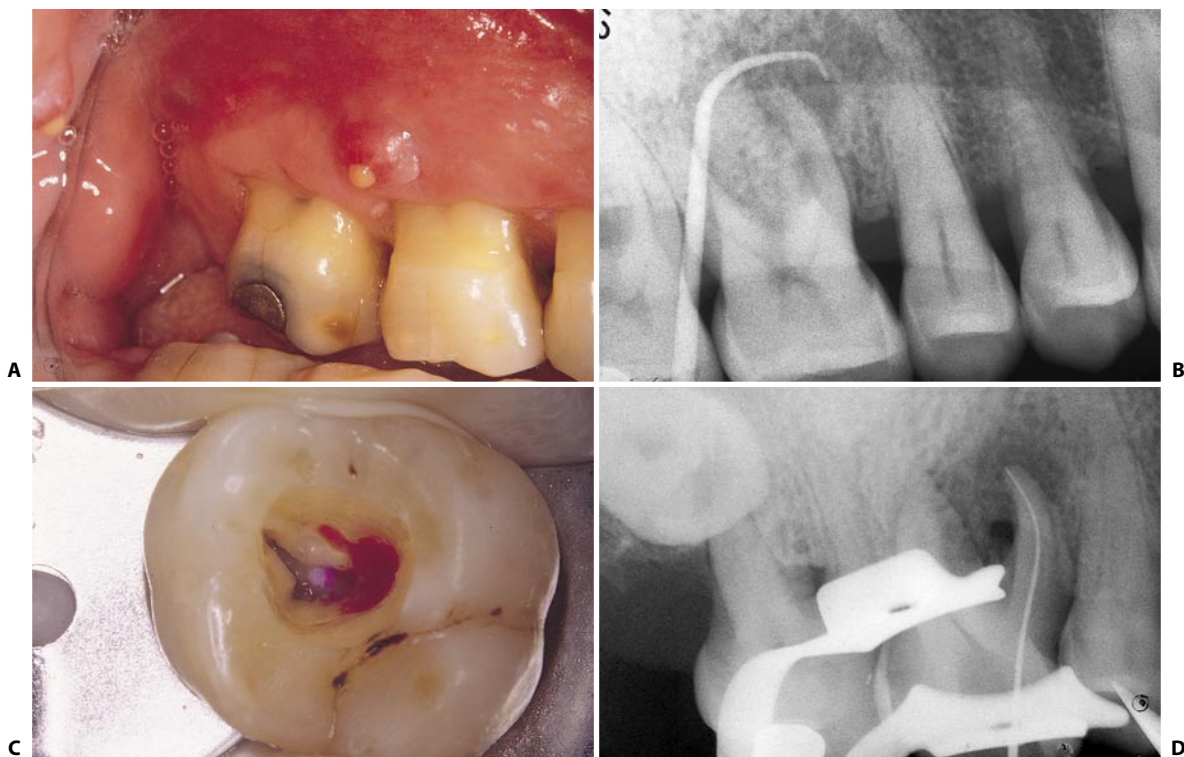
A. A fistula is present in the alveolar mucosa between the maxillary first and second molars. B. The gutta-percha cone introduced into the fistula reaches the mesiobuccal root, which has a periapical lesion. The electric test performed at the distobuccal root gave a positive response, while the responses were negative at the mesiobuccal. C. The access cavity has been made without anesthesia, and once the calcifications in the pulp chamber were removed one could appreciate the presence of vital, bleeding pulp both in the palatal and distobuccal canals. D. Without anesthesia, MB1 and MB2 have been cleaned and shaped, and then under anesthesia a pulpotomy has been performed at the orifice of the other canals (continued).
